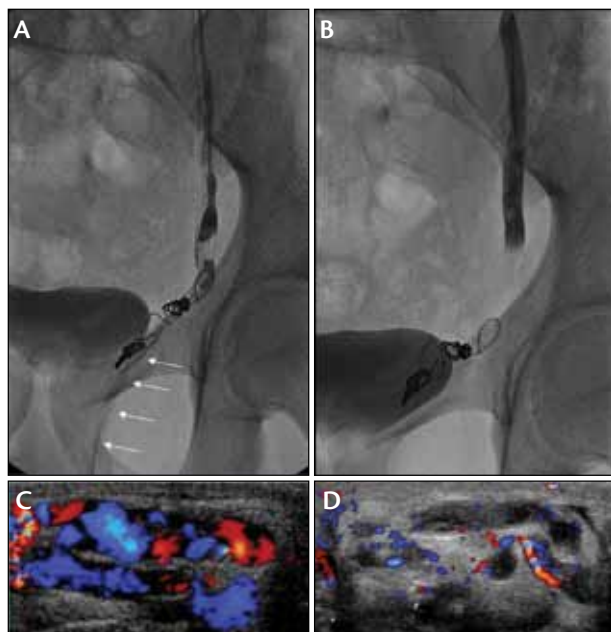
After occlusion at the inguinal canal, parallel collaterals are demonstrated (A, arrows), and they are obliterated after two injections of 3 mL of 2% STS foam (B). A second set of coils and foam were placed in the ISV at the level of the sacroiliac joint (not shown). In the ultrasound examination, a large varicocele with free reflux during a Valsalva maneuver before occlusion is demonstrated (C). At 3 months after treatment, reflux is obliterated, and one can see organized thrombus within the varicocele (D).
